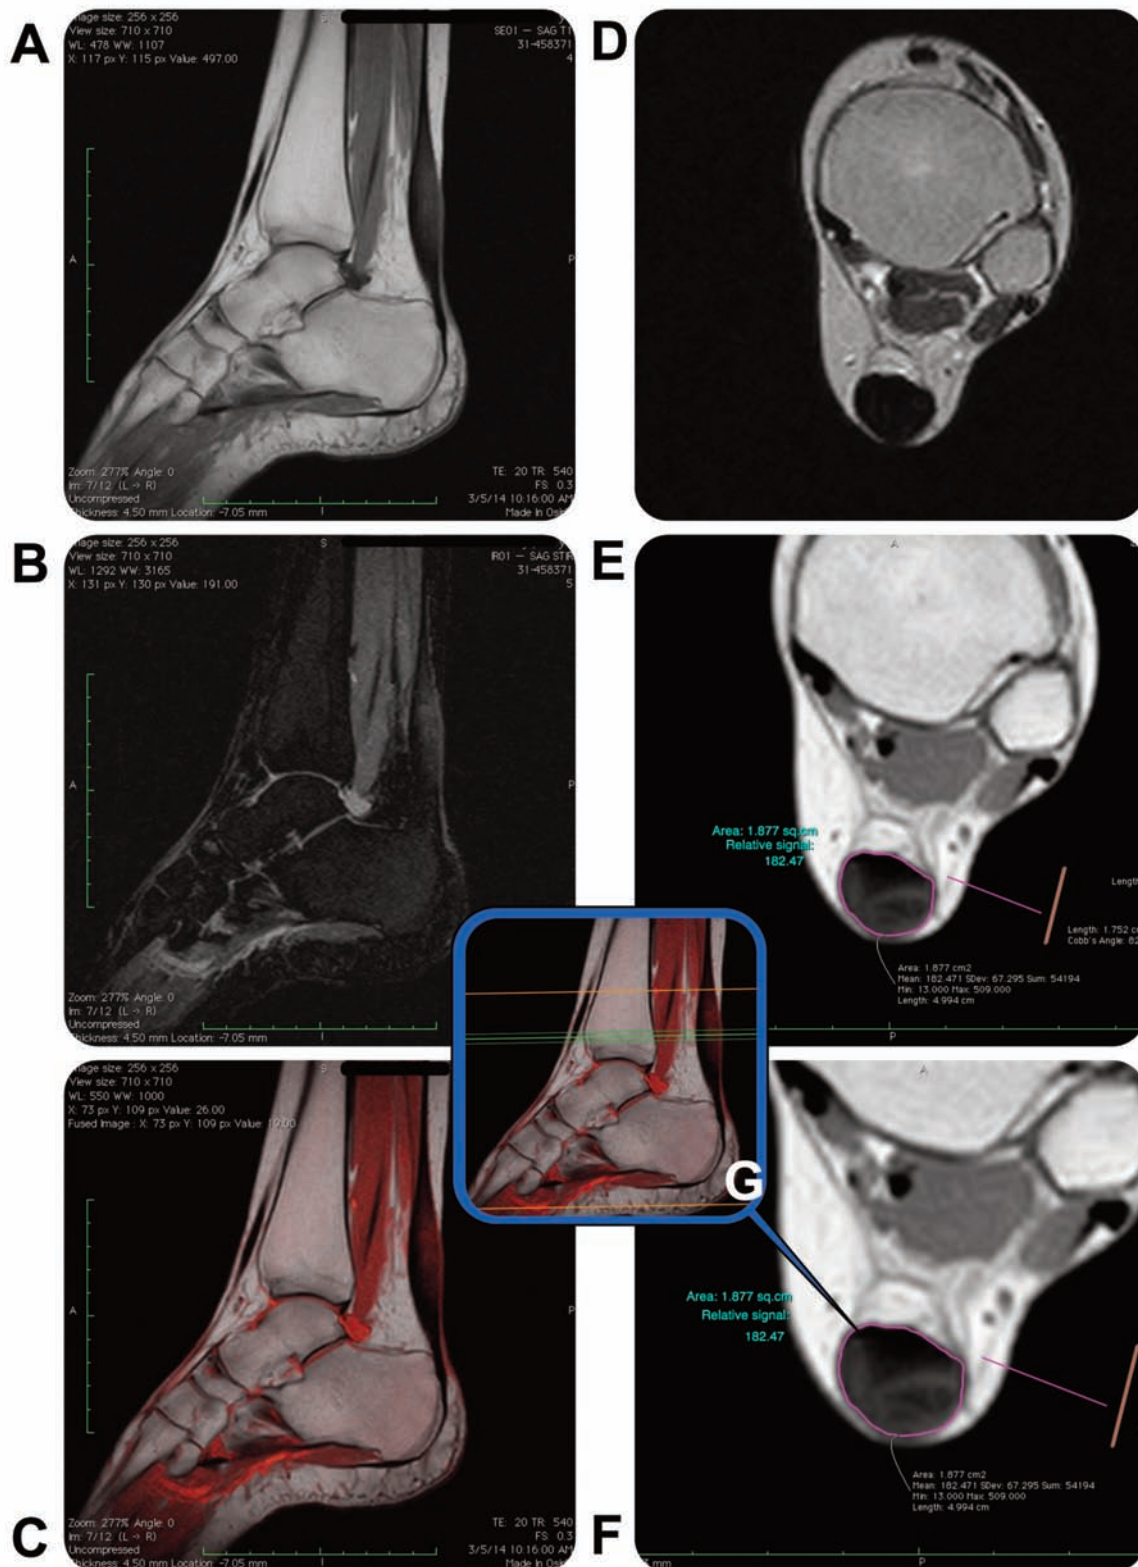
MRI of the patient's left ankle 10 weeks post-operatively, performed on a Hitachi 0.3 Tesla device. The name of the patient has been blacked out. T1 images used for calculations were both performed with a TE of 20, and a TR of 820, utilizing 5.5 mm slice thicknesses. Color fusion with OsiriX Imaging Software. *A*, Sagittal T1 left ankle. *B*, STIR Sagittal left ankle. *C*, Sagittal T1 fused with a sagittal STIR left ankle. *D*, Axial T1 left ankle. *E*, Axial T2 Fast Spin Echo left ankle. *F*, Axial T1 zoomed to better show the image measurement of signal intensity and area of involved tissue left ankle. *G*, Scout view – center green line represents the image slice in *F* taken at the most involved portion of the tendon—left ankle.
